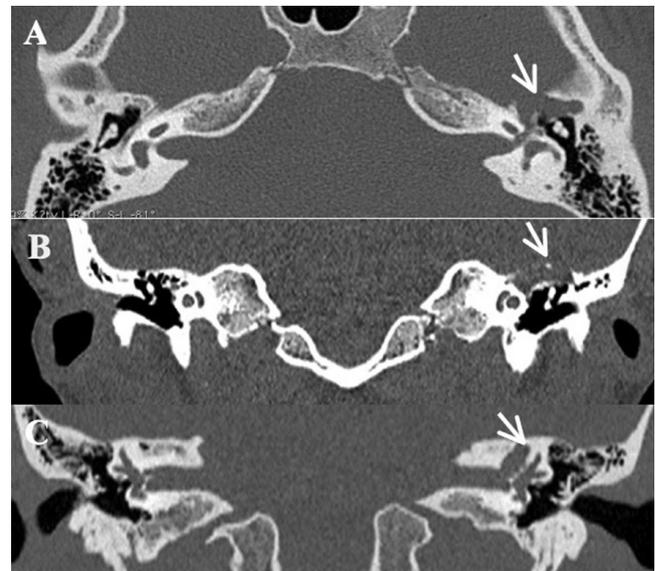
A – axial, B and C – coronal CT scans demonstrate a soft tissue mass in the left epitympanum above the head of the malleus, extending over the cochlea, destroying tegmen tympani and the upper wall of the internal acoustic meatus.
